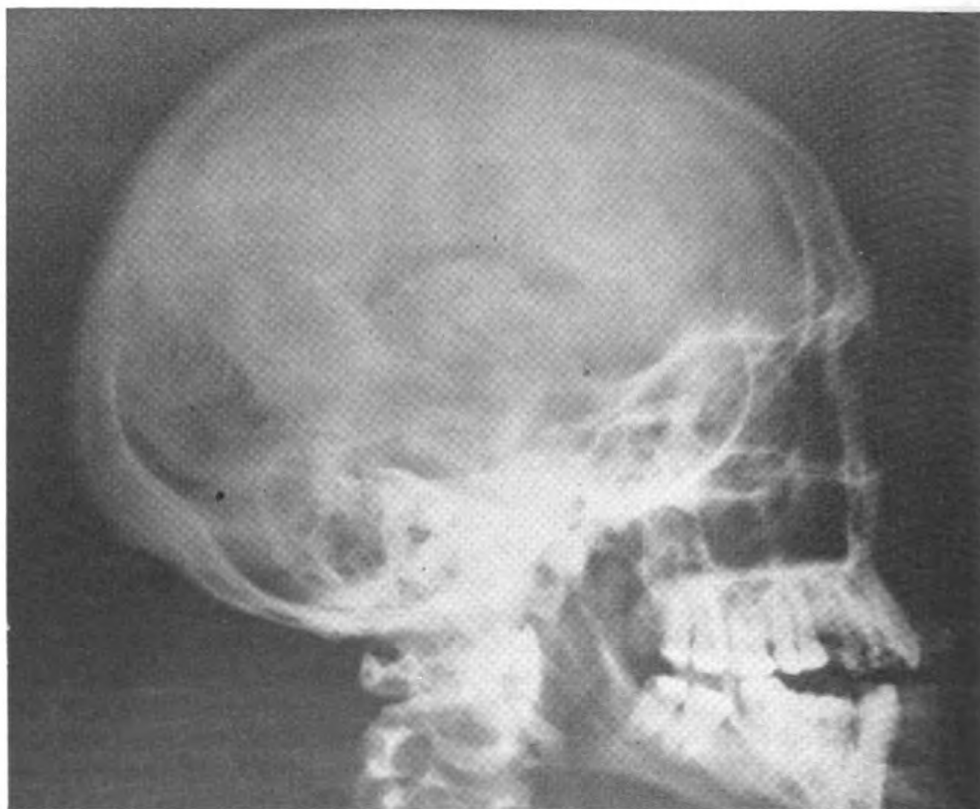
A right lateral roentgenogram of the skull, taken 12 September 1946, showing the spontaneous ventriculogram and air outlining some of the subarachnoid pathways. No fracture line was identified.
